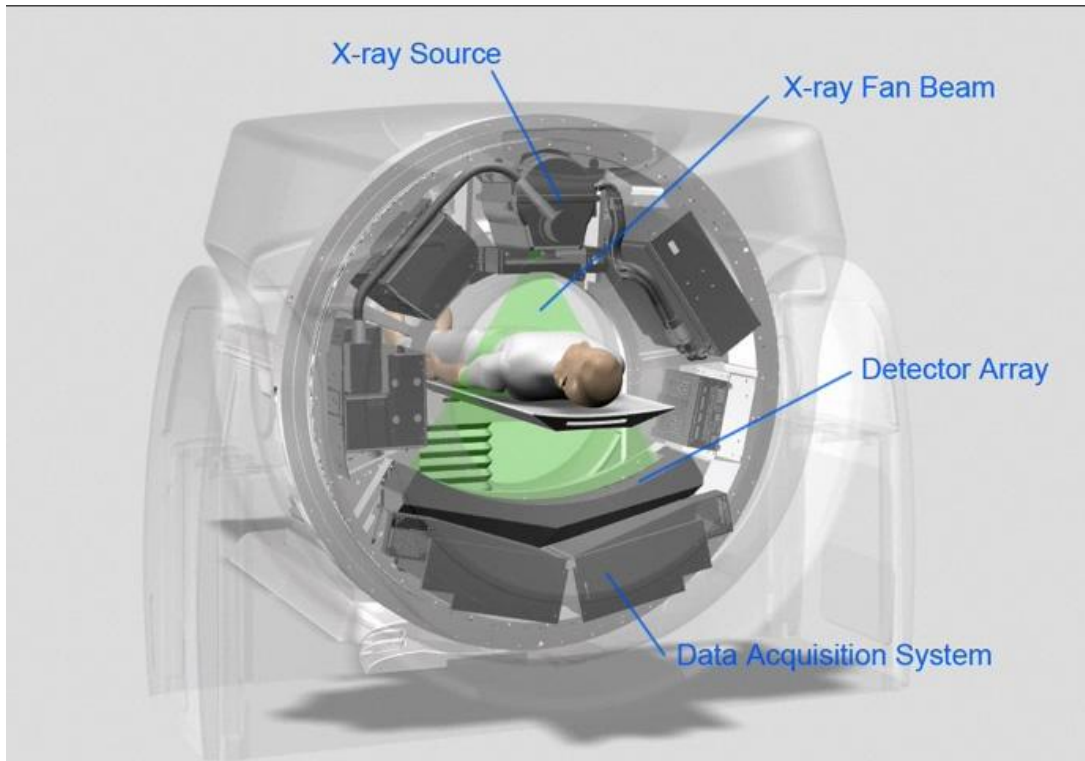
General design of a computed tomography scanning machine [35]. The x-ray tube, detector array, and data acquisition system rotates completely around the patient.
